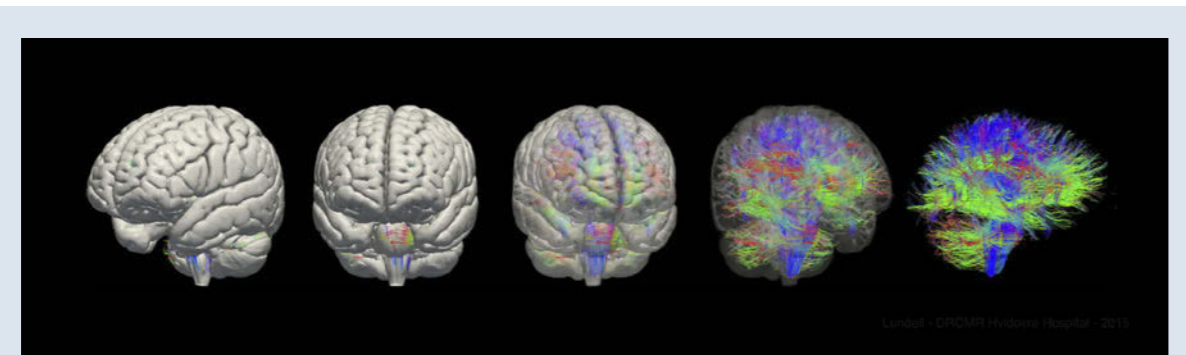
White-matter pathways reconstructed with tractography from diffusion MRI. The animation reveals the structural connections between different parts of the brain (animation by Henrik Lundell).
